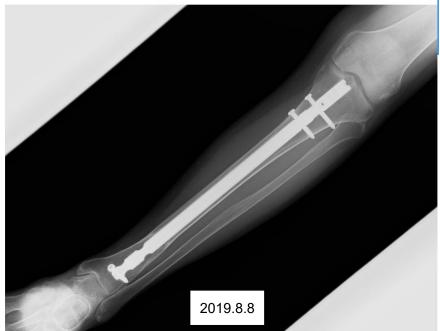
X-ray images of positive changes in her left lower extremity
